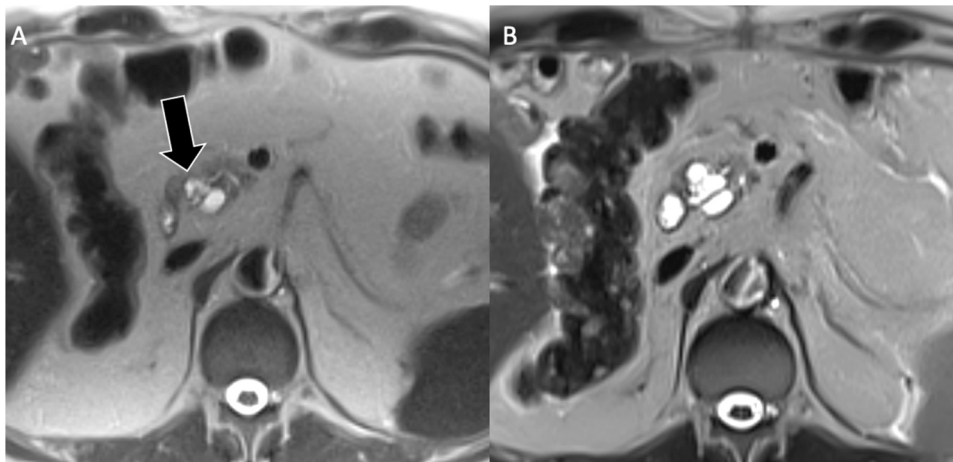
Shin scoring system. A. T2-weighted non-fat sat sequence acquired in 2014 shows a BD-IPMN (arrow) in a 54-year-old man with CA19.9 of 23.9 IU/mL, with a Shin score of 0. B. T2-weighted non-fat sat sequence acquired in the same patients in 2022 when the patient was aged 67, showed a size increase of the BD-IPMN accompanied by an increase of the CA19.9 to 109.5 IU/mL with a final Shine score of 2.
